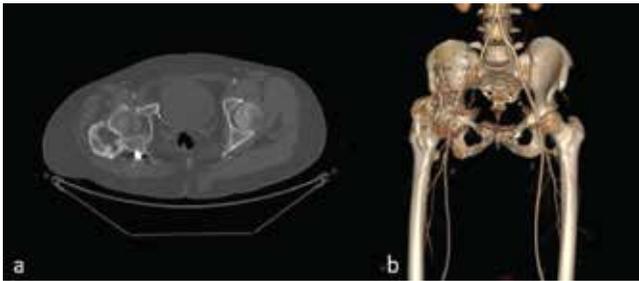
a) A Cross section of axial CT scan showing both extra articular and intra articular ankylosis b) CT angiography superimposed images showing the external iliac vessels traversing over the HO without any encasement
